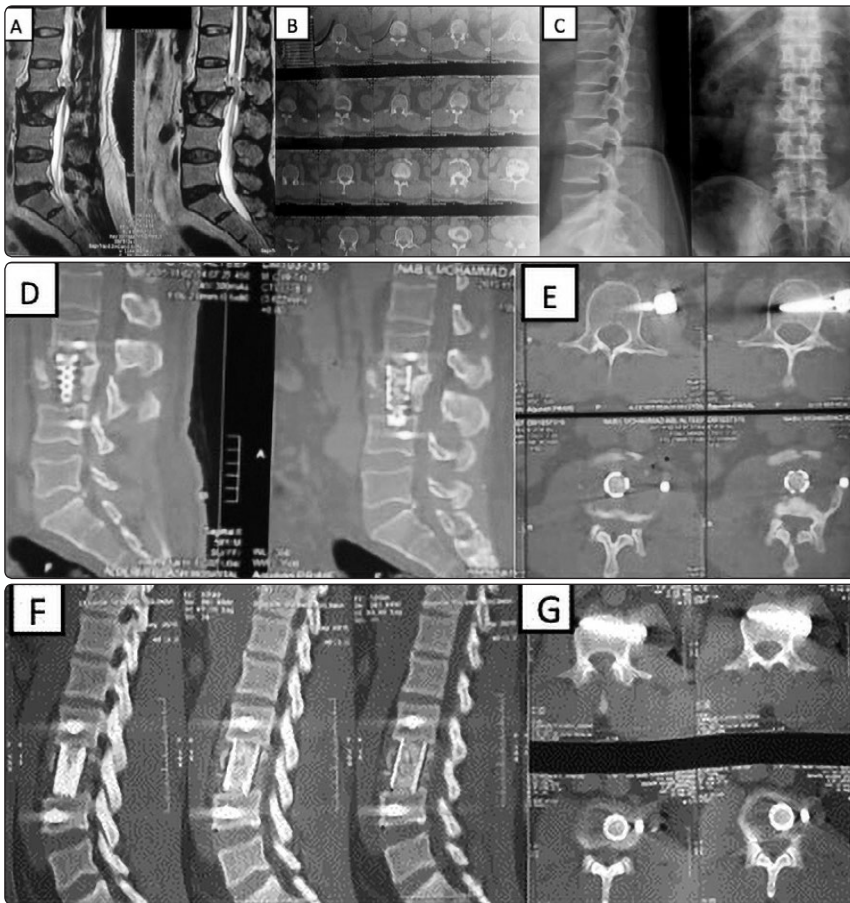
A 45-year-old male with L3 burst fracture after falling from a height. Preoperative ASIA Grade E, VAS 6, and kyphotic angle 6°. Postoperative ASIA Grade E, VAS 2, and kyphotic angle 4°. Patient was operated upon via anterior spine showing L3 burst fracture with retropulsed fragment compressing the spinal canal. (B) Axial CT cuts showing the fracture and compromised canal. (C) Preoperative AP and lateral X-ray showing L3 burst fracture. (D,E) CT scan sagittal and axial cuts early postoperative showing pyramesh, screws, and rod in place. (F,G) CT scan sagittal and axial cuts follow-up after 6 months.
